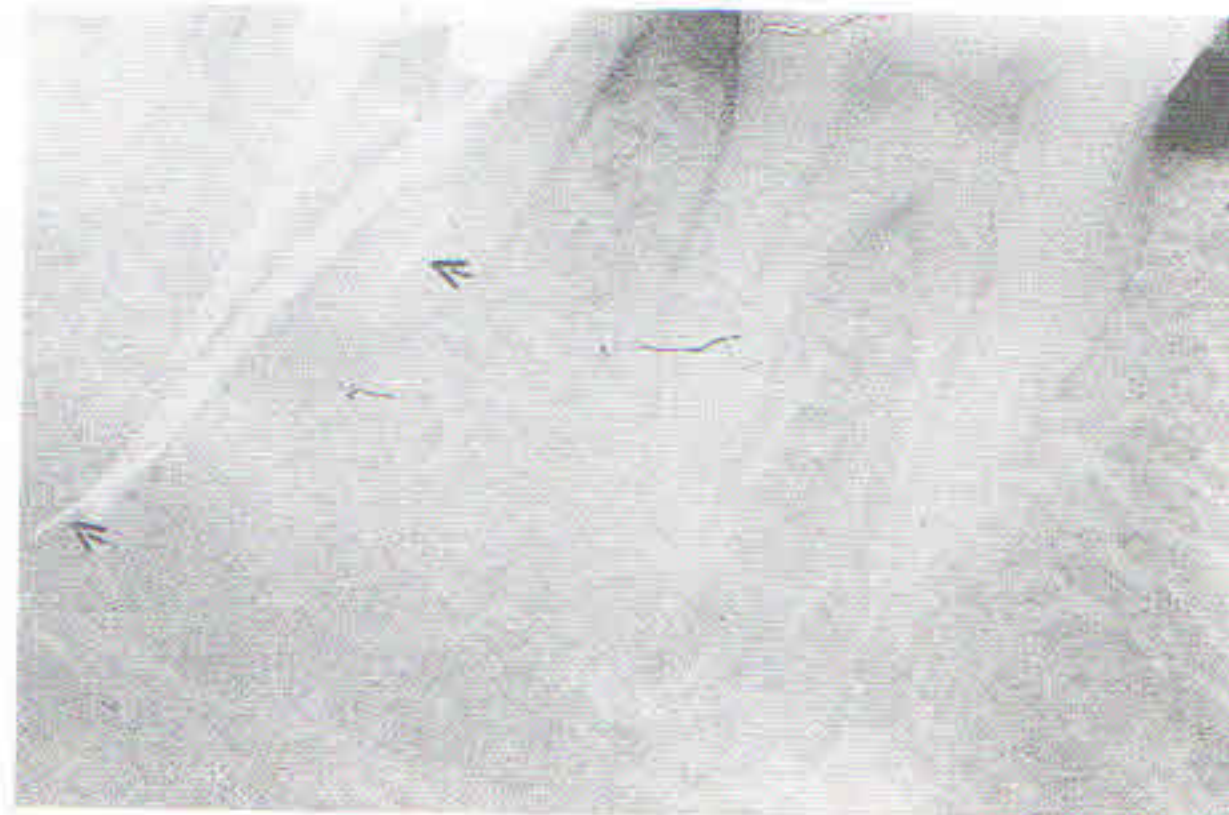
Periapical radiograph of lower right second molar showing the relationship of the extracted root filling to the inferior dental canal. Arrows show separated instrument present in the mesial canal and the inferior dental canal.
